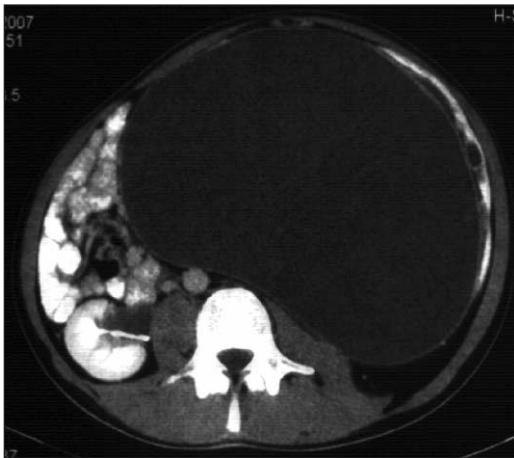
Axial CT image shows cystic mass displacing intestine
